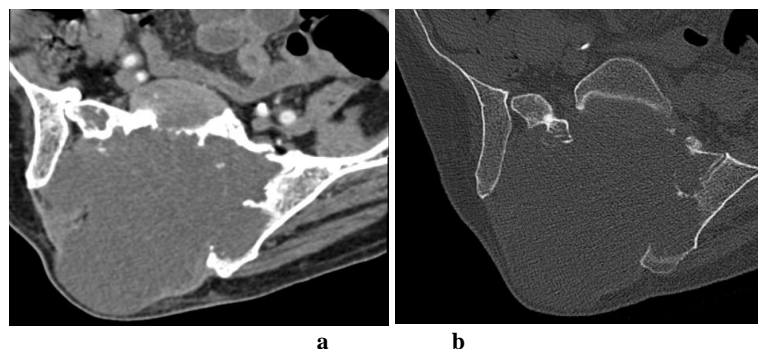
CT coronal plan
